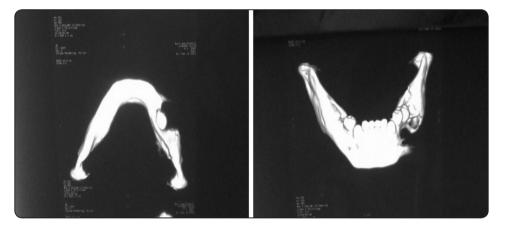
3-D CT image showing destruction of the buccal cortex & intact lingual cortex
